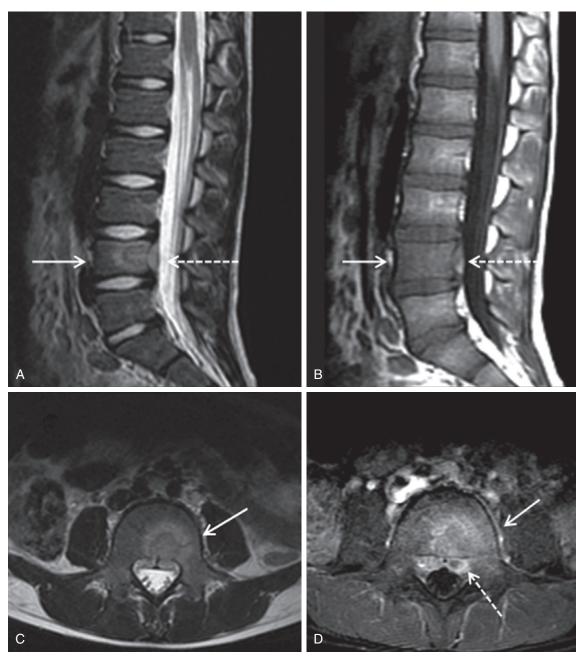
Patient presenting with back pain and fever: Osteomyelitis and epidural abscess. A, Sagittal midline T₂ MR image of the lumbar spine delineates relative hyperintensity in the L4 vertebral body (*solid arrow*) and an epidural collection (*dashed arrow*). B, Sagittal T₁ image at the same level delineates corresponding hypointensity in the L4 vertebral body (*solid arrow*) and the epidural collection (*dashed arrow*). C, Axial T₂ image at the level of L4 demonstrates an abnormal signal/hyperintensity in the vertebral body (*solid arrow*). D, Contrast-enhanced T₁ fat-saturated image at the same level delineates enhancement of the L4 vertebral body (*solid arrow*) and enhancement of the epidural collection with a small central focus of fluid hypoattenuation (*dashed arrow*).
